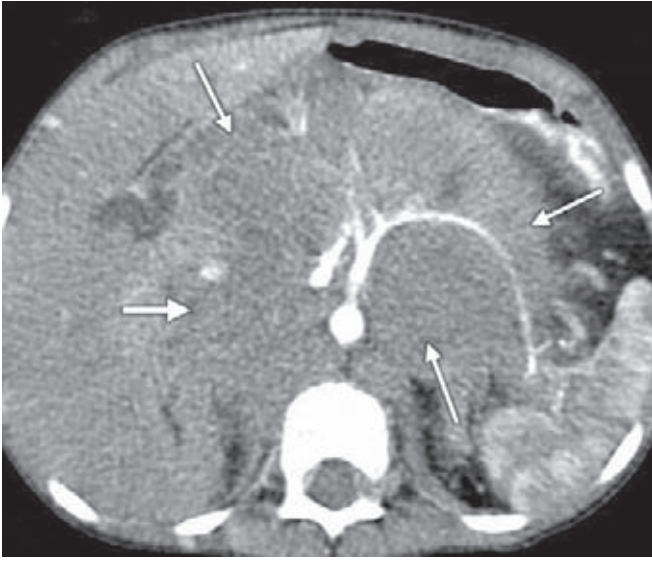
Neuroblastoma: 2 years old with neuroblastoma. An enhanced CT image shows a retroperitoneal mass with vascular encasement (arrows)
